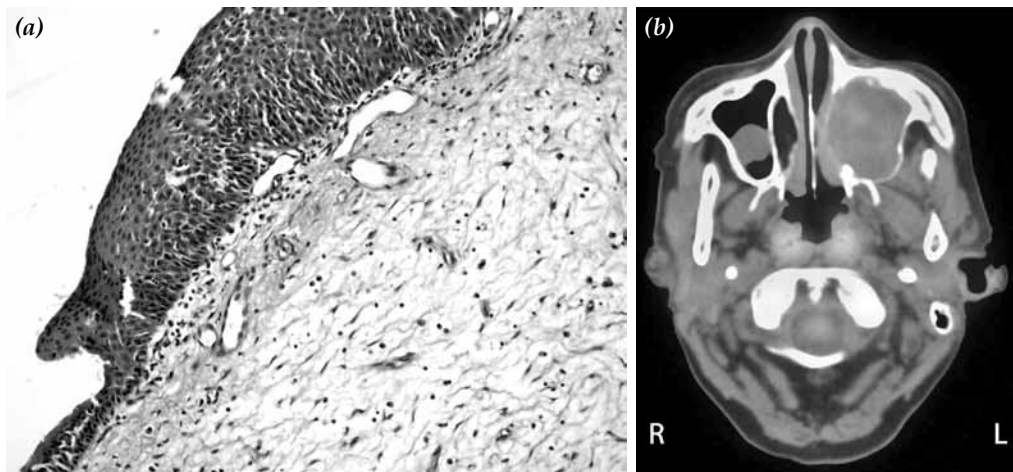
In polyp, (a) inflammation extending to surface epithelium, rich in eosinophils (H-E x 400). (b) Positron emission tomography/computed tomography image of the same patient.
